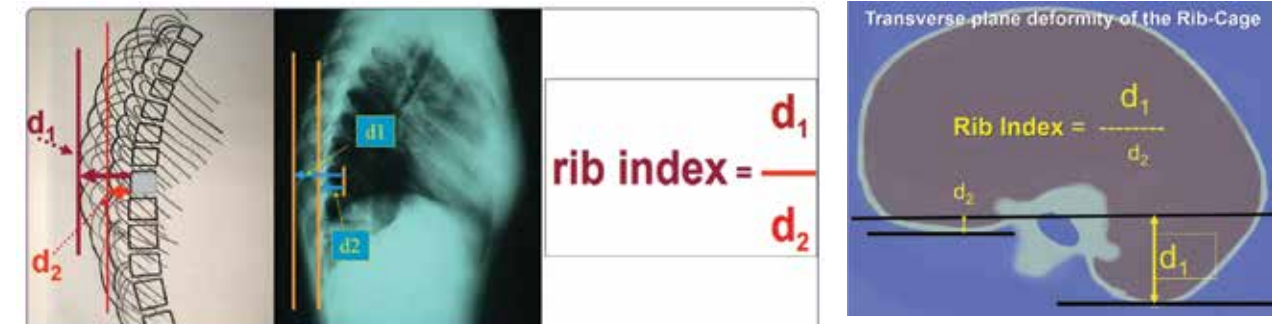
The DRCS and the RI in the lateral thoracic radiographs used for the thoracic transverse plane deformity assessment, (Modified from [56]).
